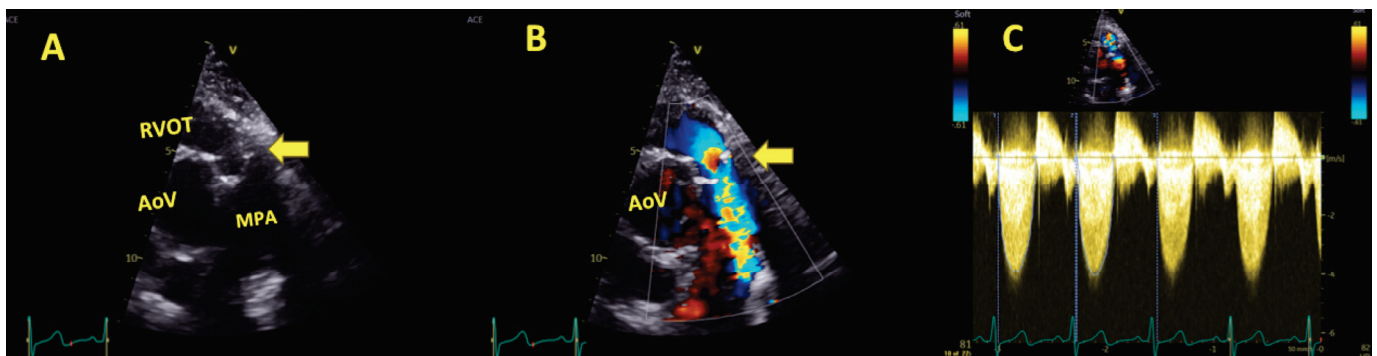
Panel (A) Parasternal short-axis (PSAX) view at aortic valve level short-axis (PSAX) view showing severe homograft stenosis with degenerative homograft cusps (yellow arrow) RVOT and MPA. Panel (B); color Doppler demonstrating systolic flow acceleration starting at the level of pulmonic homograft (yellow arrow) indicating pulmonic valve stenosis (PS). Panel (C); Continuous-flow (CW) Doppler across the pulmonic valve showing severe PS with peak and mean gradients of 69 and 42 mmHg, respectively; Abbreviations: AoV: aortic valve, RVOT: right ventricle out-flow tract, MPA: main pulmonary artery.
